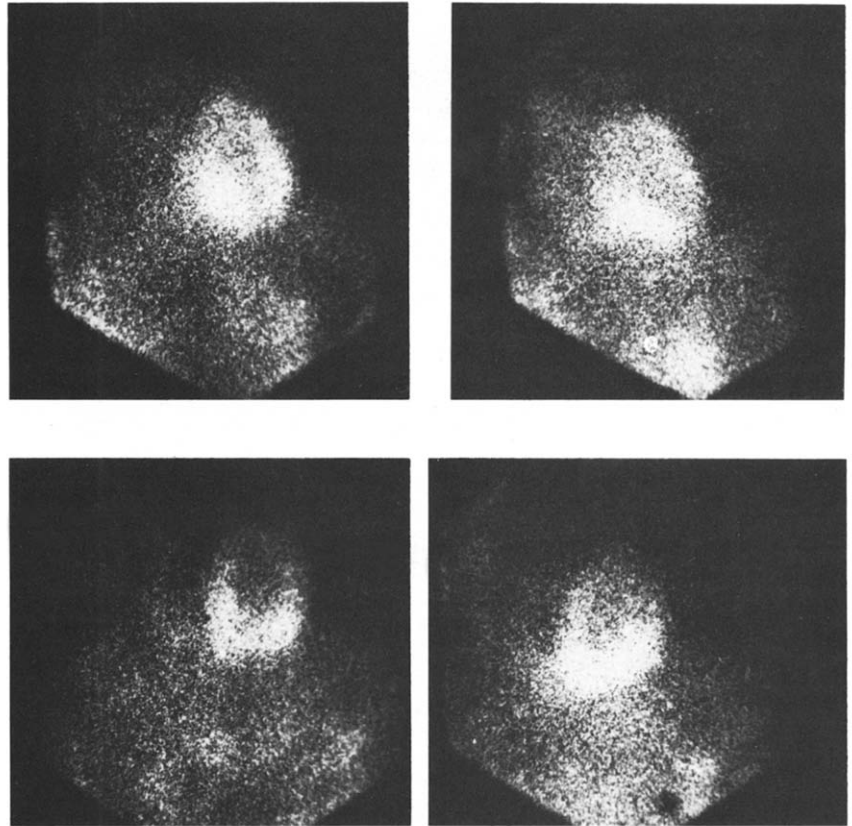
Patient 4. Stress (left) and redistribution (right) thallium scintigrams obtained in the anterior view. There is decreased uptake of thallium in the inferior and anterolateral segments during stress. The redistribution image reveals increased uptake in these areas.
